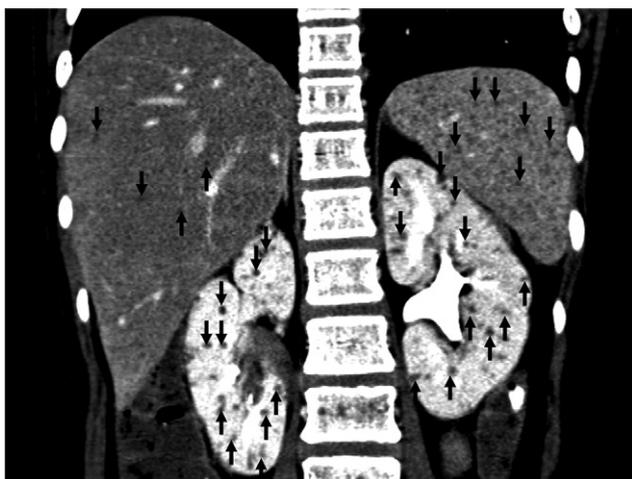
Computed tomography scan after recovery from nadir post-chemotherapy reveals radiological multiple hypodensities within the liver, spleen, and bilateral kidneys (arrows).
